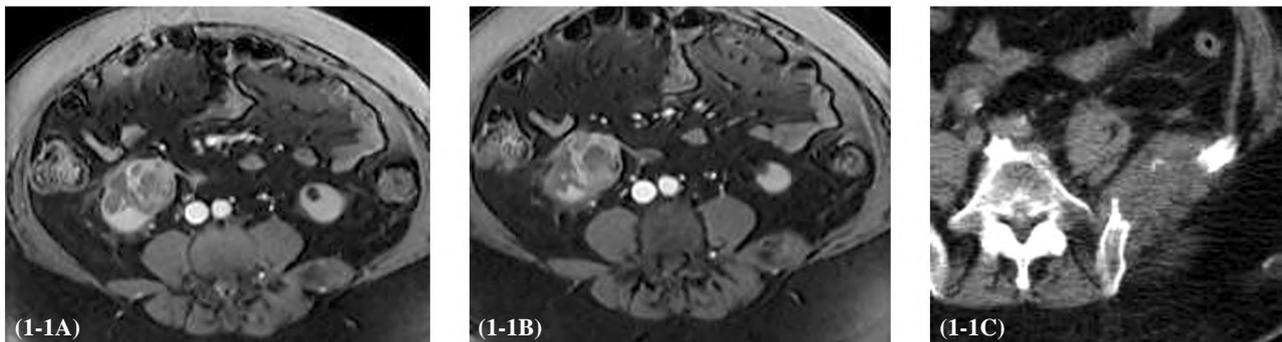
A, B: Post contrast Axial MRI images shows ill-defined enhanced lower pole right renal mass (6 X 7cm) with infiltration the perinephric fat plans, C: Axial CT image of the pelvis shows destructive left iliac metastatic soft tissue mass lesion.
